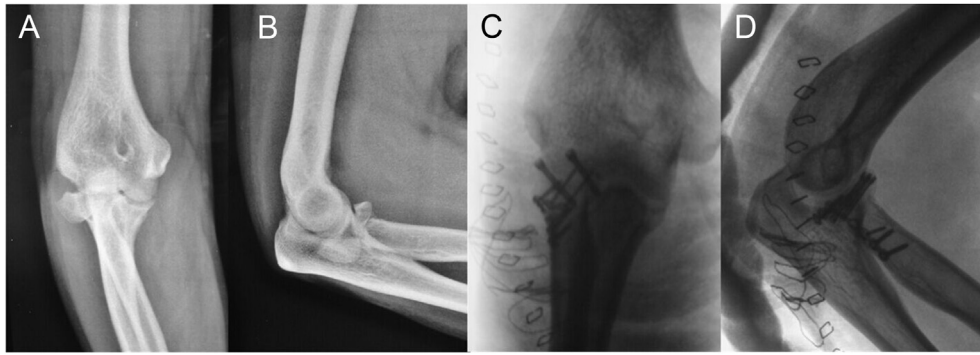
Anteroposterior (A) and lateral (B) radiographs of a 25-year-old patient showing Mason type III radial head fracture. Immediate postoperative radiographs after on table radial head reconstruction and fixation (C and D).
